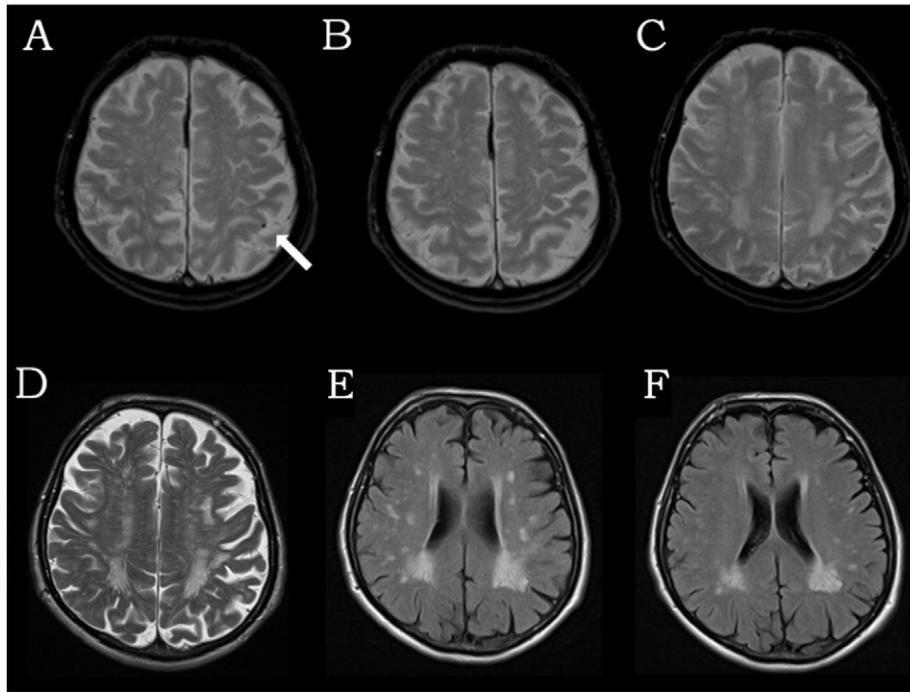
Gradient-echo axial brain-MRI performed during the first 48 h following symptom onset showing a left parietal microbleed (arrow, panel A) that was not present in previous MRI performed 9 months ago (panel B). Note the presence of older multiple cortical microbleeds with "blurred" appearance on gradient-echo MRI (panel C). Axial T2-weighted imaging shows flodid perivascular spaces in the centrum semiovale (panel D). Posterior distribution of white matter lesions (WMLs) on axial FLAIR MRI (panel E). This characteristic distribution of WMLs has been already present 4 years before admission on a brain MRI that has been ordered after an episode of vertigo (panel F).
